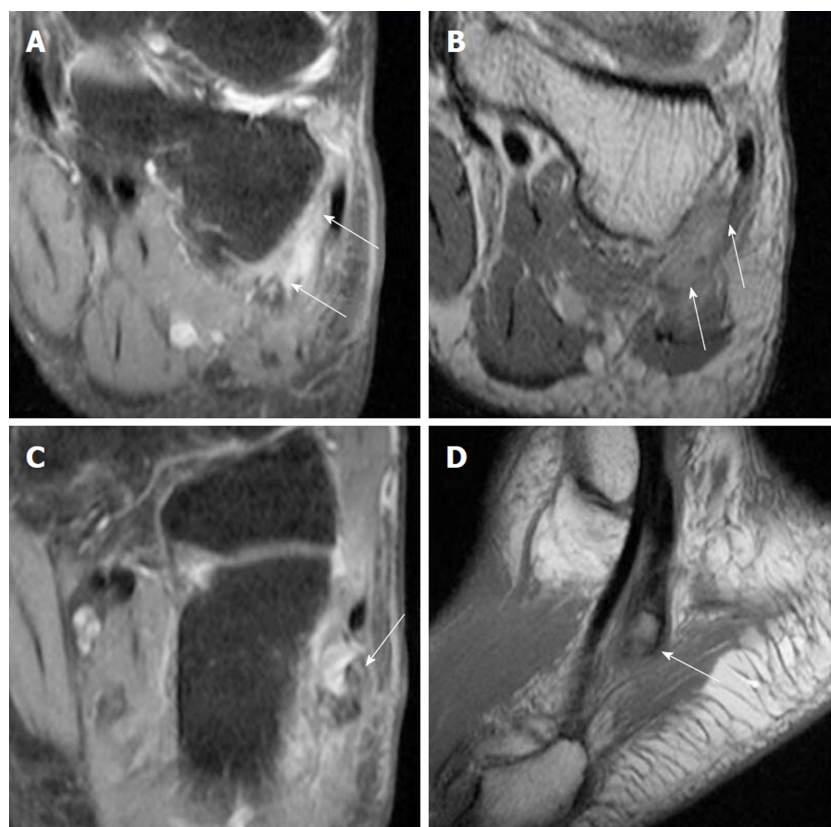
Magnetic resonance imaging of left foot. A: (Coronal) Peroneal tenosynovitis; B: (Coronal) Both peroneal tendons run within a flat peroneal groove with intact superior peroneal retinaculum. No fixed lateral subluxation of the peroneal tendons; C, D: (Sagittal view). Five millimeter os peroneum within the peroneus longus tendon (PLT), with full-thickness rupture of the PLT. The tear measures 2 cm in length, with proximal migration of the tendon at the level of the cuboid bone.
